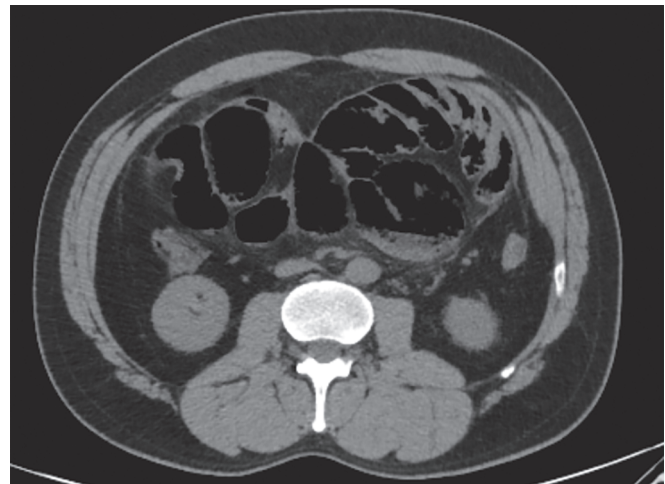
CT axial image of abdominal cocoon
